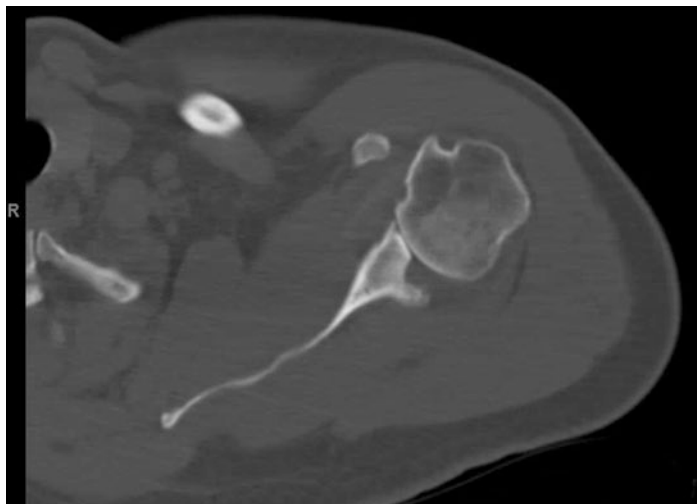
Axial CT scan showing degeneration of humeral head and glenoid
